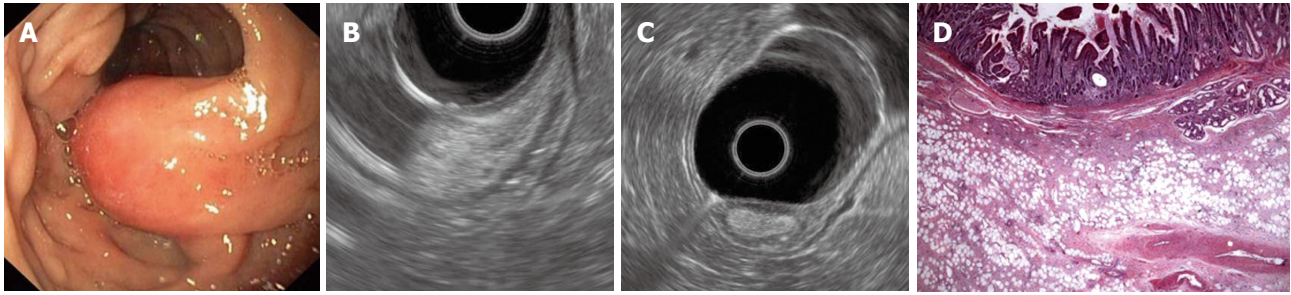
Endoscopic, endoscopic ultrasonography and pathological findings of hamartomatous polyp. A: Semipedunculated polyp in the second portion of the duodenum; B: Longitudinal view of the polyp's stalk-originating from the duodenal wall; C: Top of the polypoid lesion-cross-sectional view; D: Hamartomatous polyp, HE $\times 25$.
